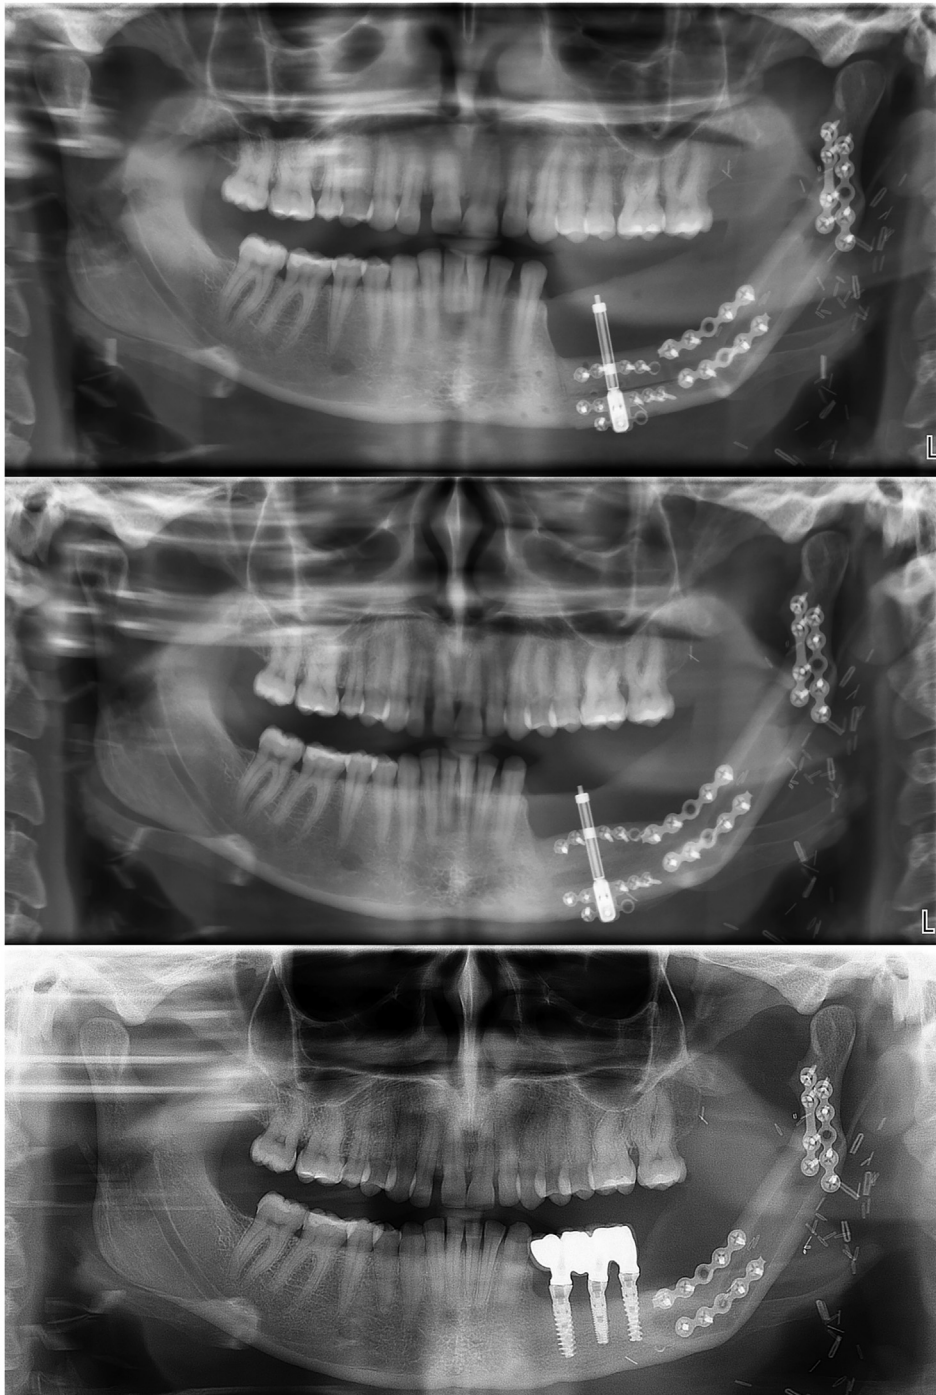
Case 3. Panoramic x-ray images. Top: at the beginning of osteodistraction; Middle: at the end of osteodistraction; Bottom: at the 4-year follow-up.
